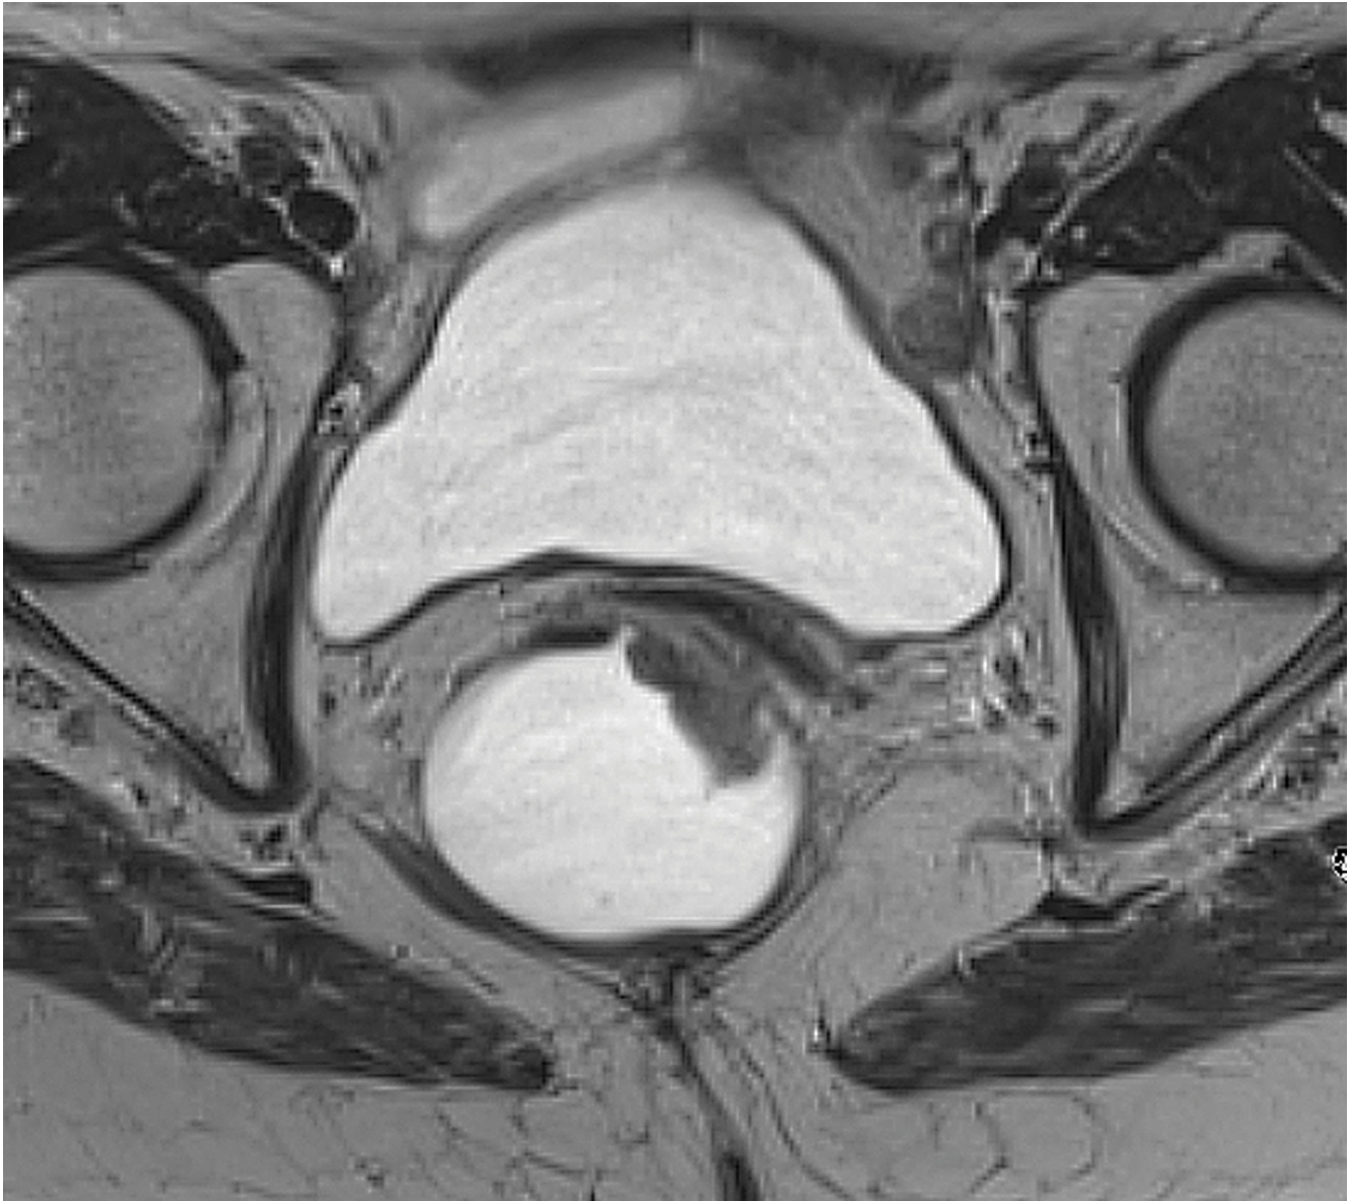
Axial T2W pelvic MRI in a 79-year-old female who underwent rectal filling. A sessile tumor between 12–2 PM is either T1 or T2 – but careful scrutiny of the muscularis propria shows its full preservation at the epicenter of the lesion indicating greater certainty of mrT1 stage and potentially amenable to local excision by TEM or TAMIS.
